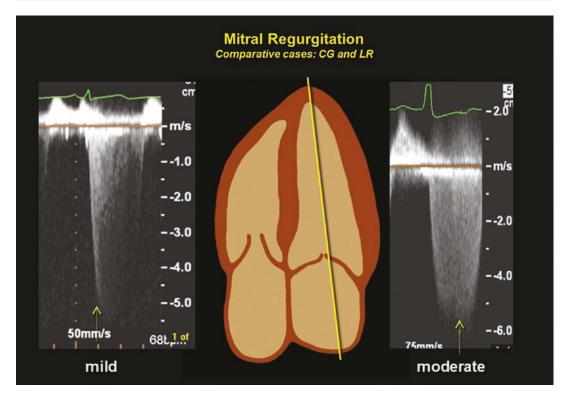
Two contrasting continuous wave recordings of mild and more sever mitral regurgitation from two different patients. One can also use the intensities of the Doppler recordings to indicate severity of regurgitation. See text
